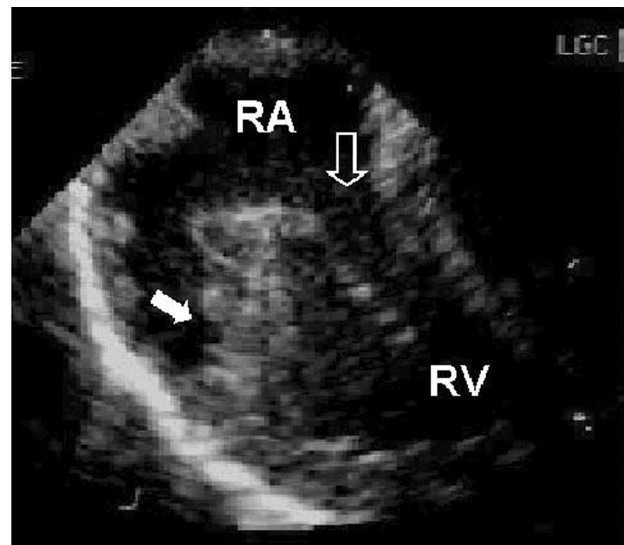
Trans-esophageal echocardiogram (horizontal plane) done in the early post-operative period showing a pouch in the right atrium (RA) which communicates with the right ventricle (RV) via the smaller orifice. The larger orifice of the tricuspid valve is shown by the arrow.
